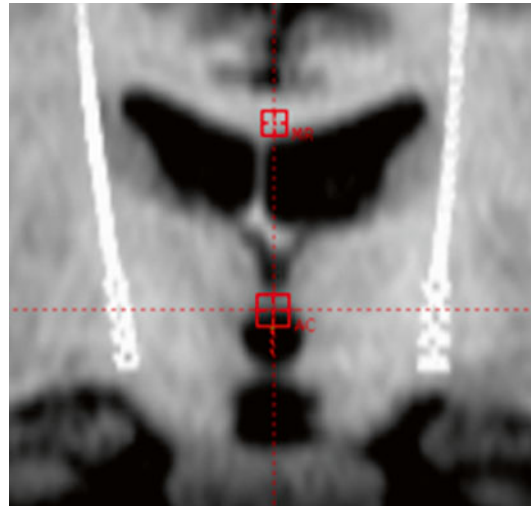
Postoperative fusion image of MR and CT to identify the location of each contact. AC level of anterior commissure, MR midline reference
